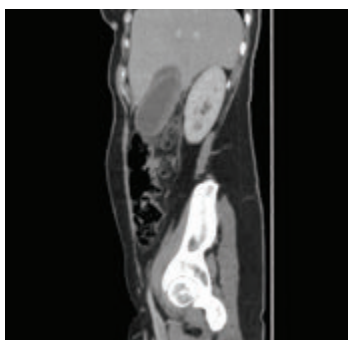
Sagittal enhancing computed tomography image of the abdomen revealing inflammatory changes of the gall bladder.
